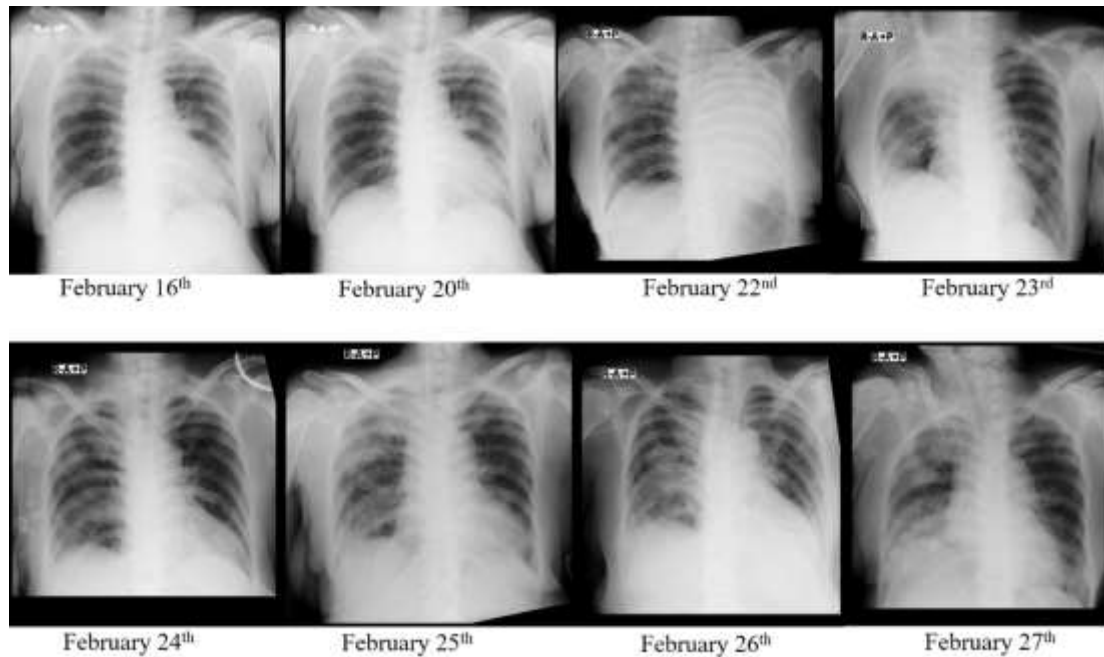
Serial chest x-ray
